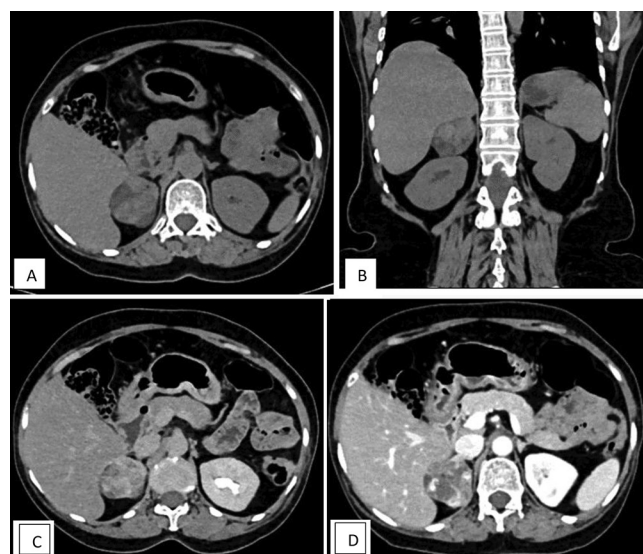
A: Axial unenhanced; B: Coronal unenhanced CT showing heterogeneous lesion in right suprarenal gland. C: Axial 1 min; D: 15 min delayed scans showing heterogeneous enhancement with nonenhancing areas and persistent contrast enhancement
